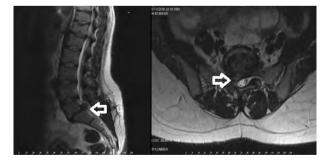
Sagittal and transvers T2-weighted lumbar MRI (postoperative) showed that right paramedian extruded disc herniations are smaller than in the previous image in the L5-S1 disc level
